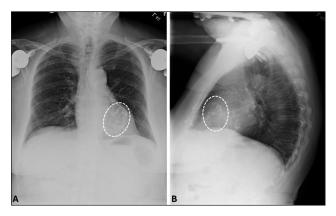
(A) Postero-anterior and (B) lateral radiographs clearly delineate the calcification within the heart tissue (white, dotted ovals), with the absence of hilar lymphadenopathies or other features suggestive of sarcoidosis.
